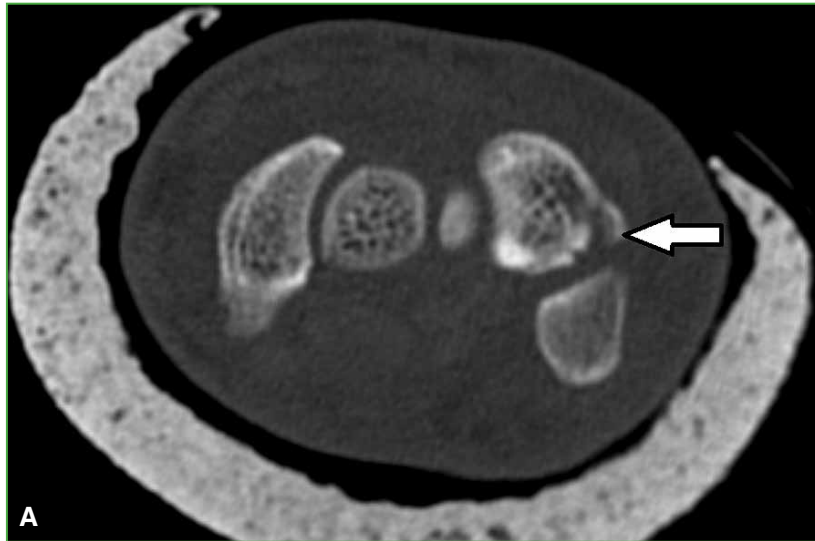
Wrist fractures of two athletes. CT transverse sections show a pisiform bone fracture (A) and a triquetrum bone fracture (B) (arrows) of one of the athletes. MRI transverse section at T1 and coronal-STIR sequence shows an ulnar fracture (C and D) of another athlete.
